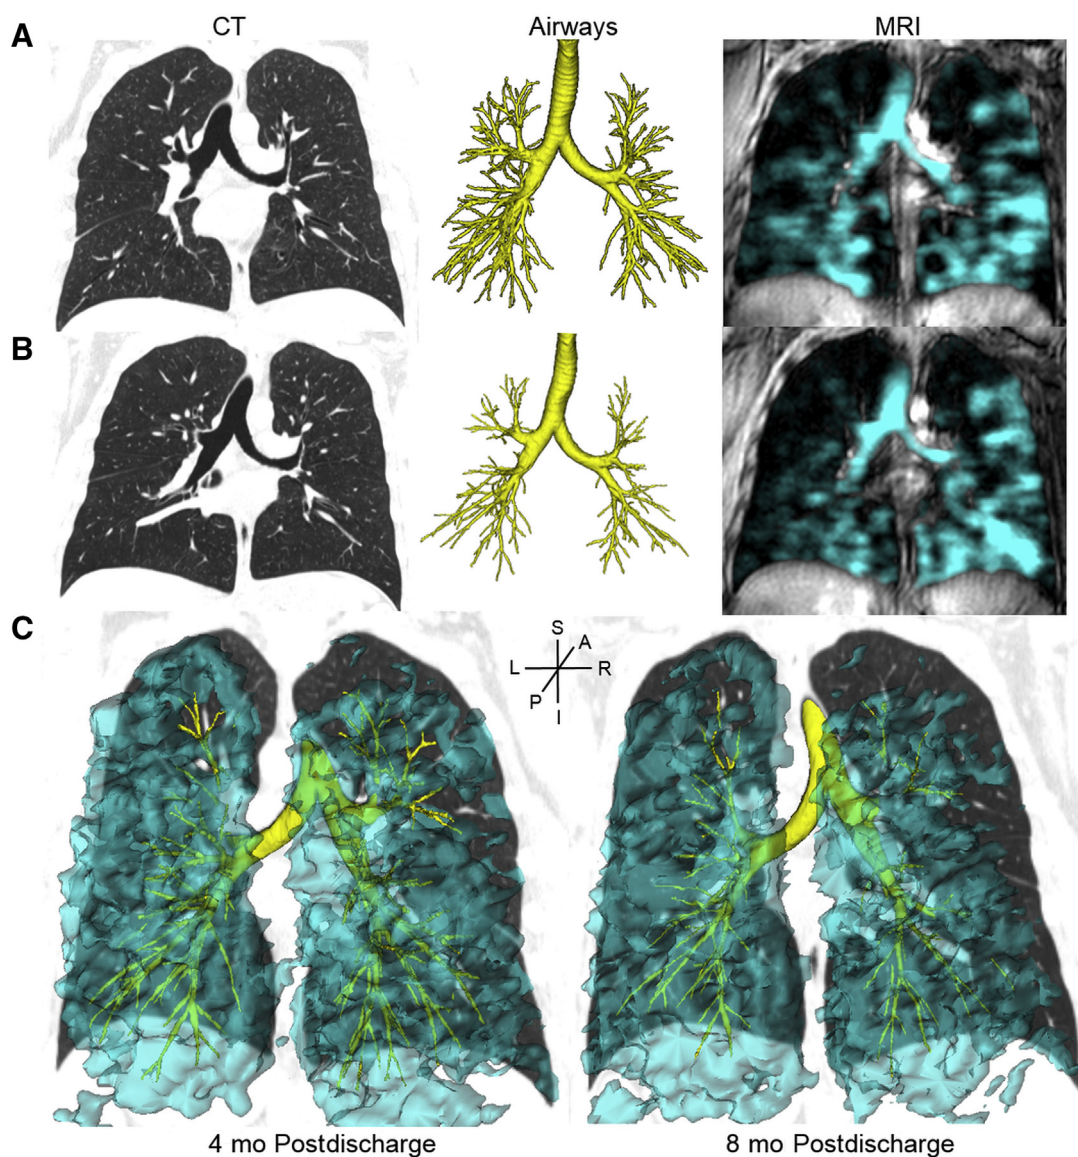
CT and MR imaging after hospital discharge. A, thoracic CT and segmented 3D airway tree acquired 1 month postdischarge and coronal center slice ^{129}Xe ventilation (cyan) co-registered to anatomic ^1H (grayscale) 4 months postdischarge. B, thoracic CT and segmented 3D airway tree acquired 7 months postdischarge as well as ^{129}Xe MRI acquired 8 months postdischarge. C, coronal reconstructed CT co-registered with MRI to highlight structure-function relationships 4 (left) and 8 months (right) postdischarge.
